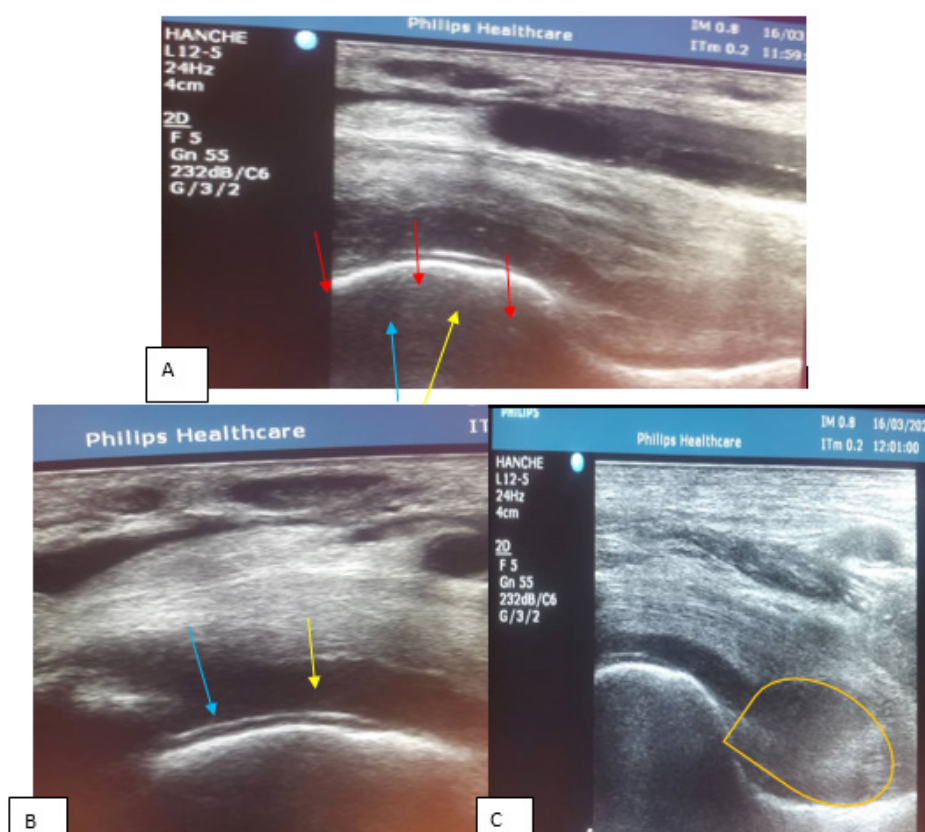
A: ultrasound of the left hip: longitudinal section of the hip joint visualizing the femoral head and neck: we can note the presence of a double contour at the level of the femoral head (blue arrow), a effusion of medium abundance with hyperechoic spots in the form of a snowstorm image (red arrow).
